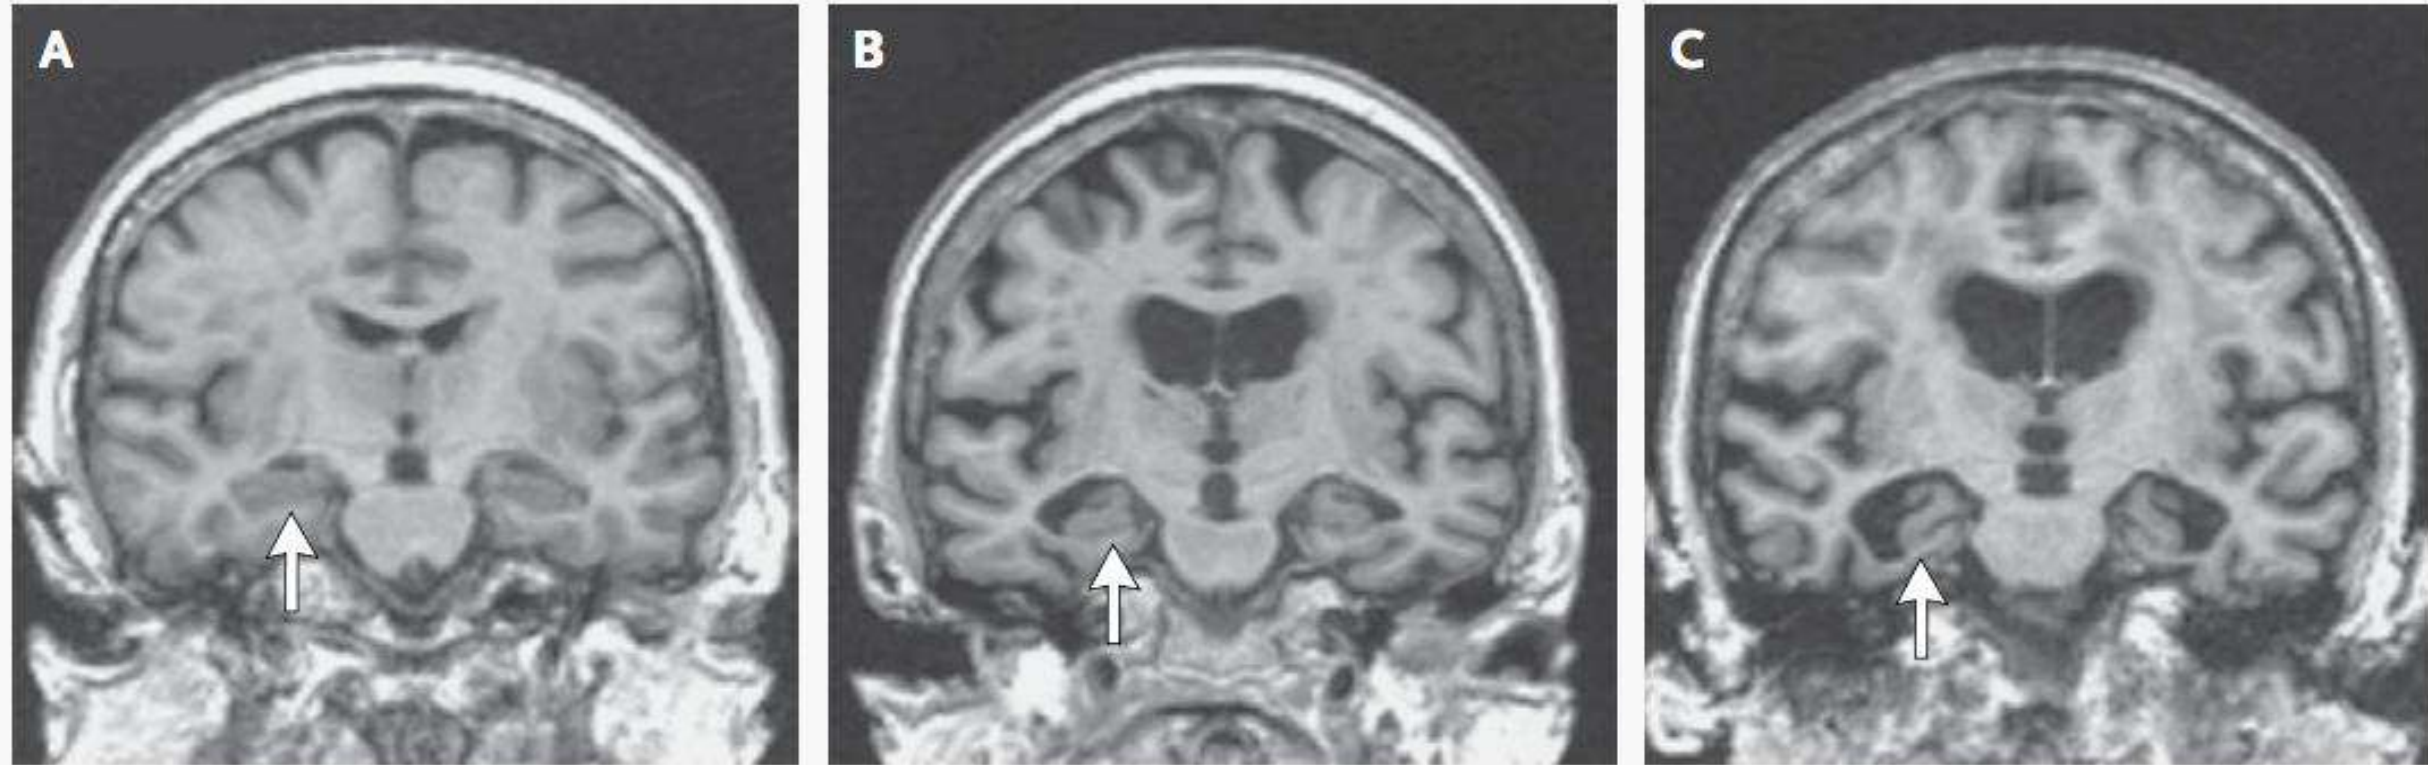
Coronal MRI Scans from Patients with Normal Cognition, Mild Cognitive Impairment, and Alzheimer's Disease.
